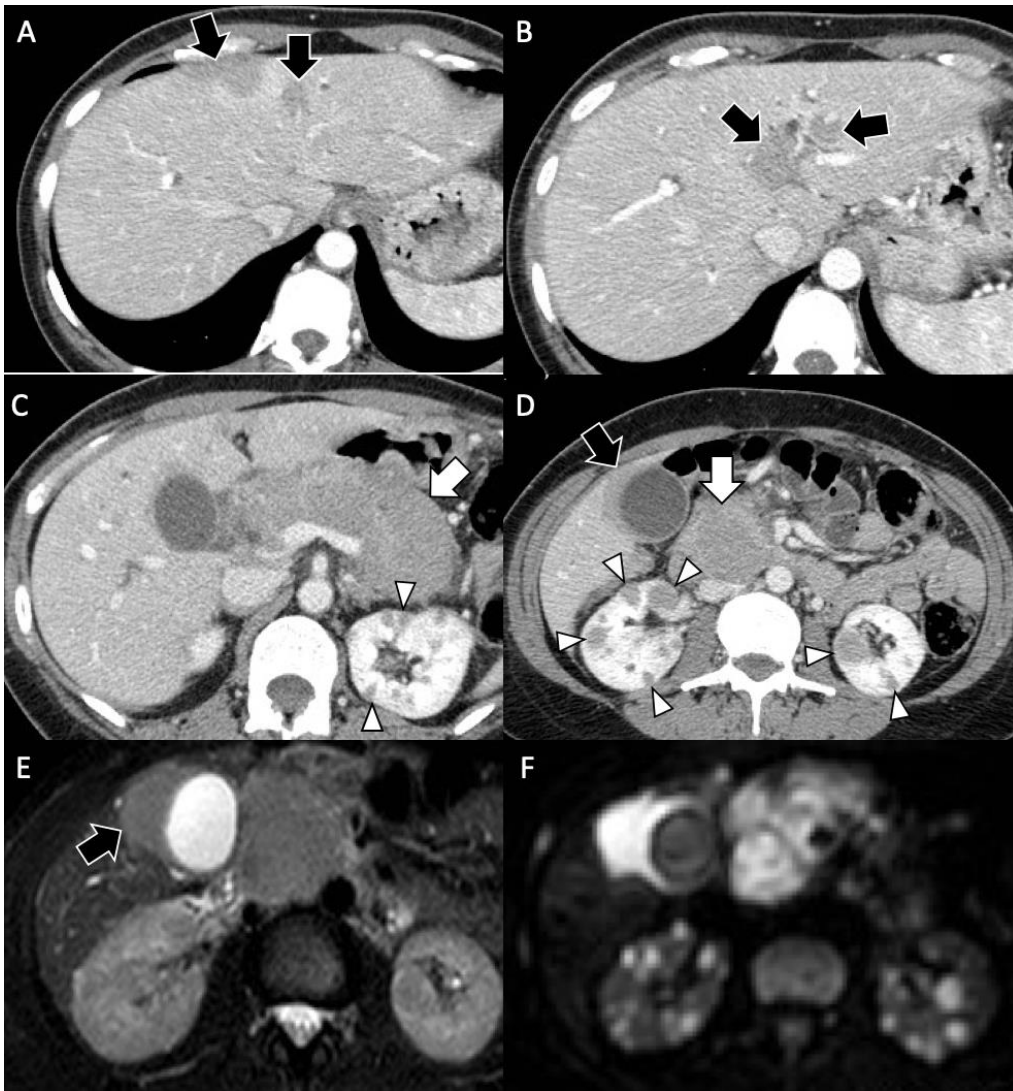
54-year-old woman with B-cell lymphoma; symptoms at diagnosis included abdominal pain and unintentional weight loss (about 3 kilos in one week). Contrast enhanced CT images on (a, b) arterial and (c, d) portal venous phases show multiple hypoattenuating liver lesions (black arrows) alongside the portal branches, an enlarged and hypoattenuating pancreas (white arrow) as well as multiple bilateral tiny hypoattenuating renal lesions (arrowheads). Liver biopsy was performed and proved the diagnosis of B-cells lymphoma, morphologically consistent with Burkitt Lymphoma. MRI (e) on T2-weighted images show one of the lymphomatous lesions (arrow) slightly hyperintense on T2-weighted, with (f) restriction on diffusion weighted image. (f) Diffusion weighted image shows also diffusion restriction of the renal lesions.
